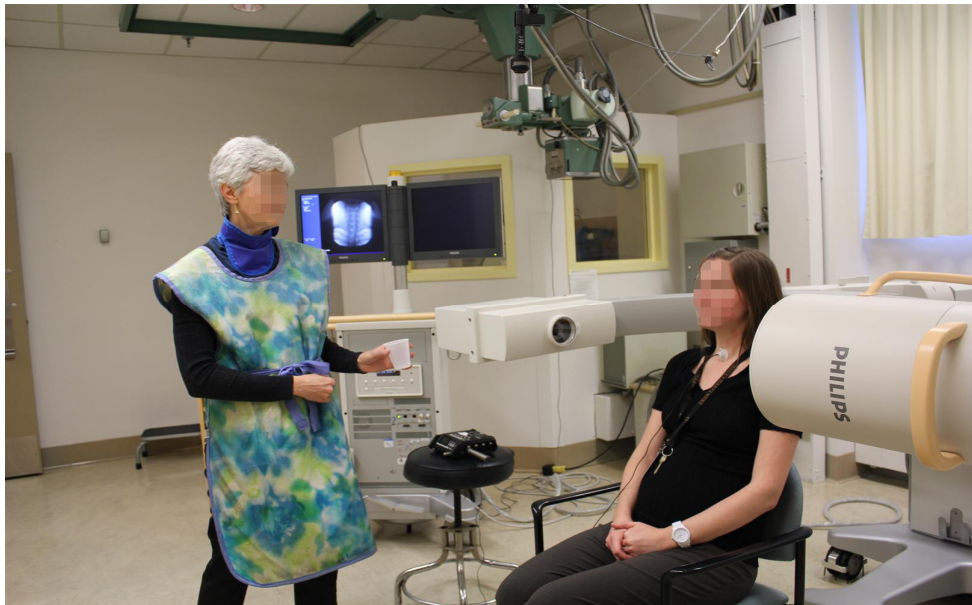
The VFS setup for swallowing assessment. The individual is given barium coated food or liquid while the x-ray images are displayed and recorded.
